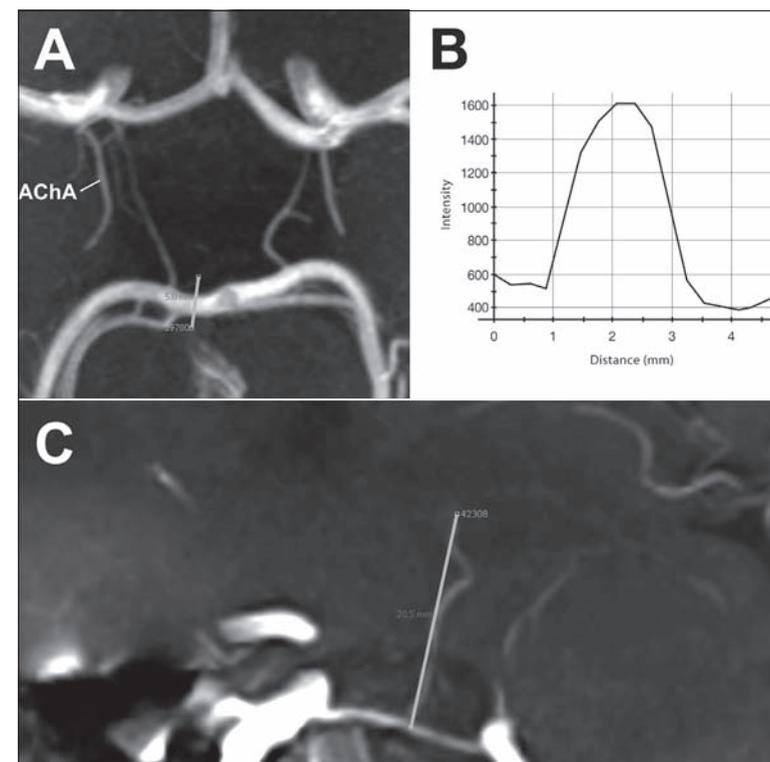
[A] Time-of-flight angiography image of the circle of Willis and the anterior choroidal artery (AChA) on 7 Tesla MRI, transversal slab maximum intensity projection (thickness 7mm). A line was set perpendicular to the left P1 and the corresponding intensity profile [B] is shown. [C] This image shows the posterior communicating artery with a perforating branch on a sagittal slab maximum intensity projection (thickness 7mm). A line was set from the origin of the perforator to the last point at which the perforator was visible to obtain a rough estimate of the length of the perforator
